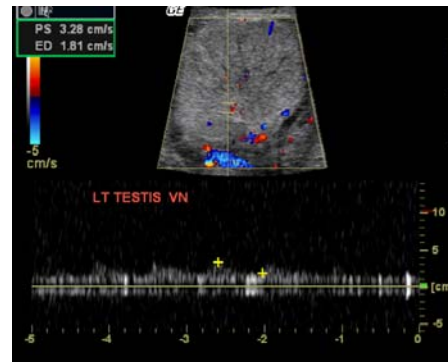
Color Doppler venous waveforms revealing blood flow to the left testicle.
